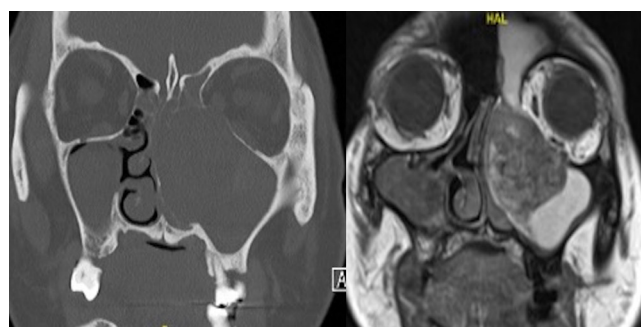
Coronal views of computed tomography paranasal sinuses bone window and T1-weighted magnetic resonance imaging with contrast.
